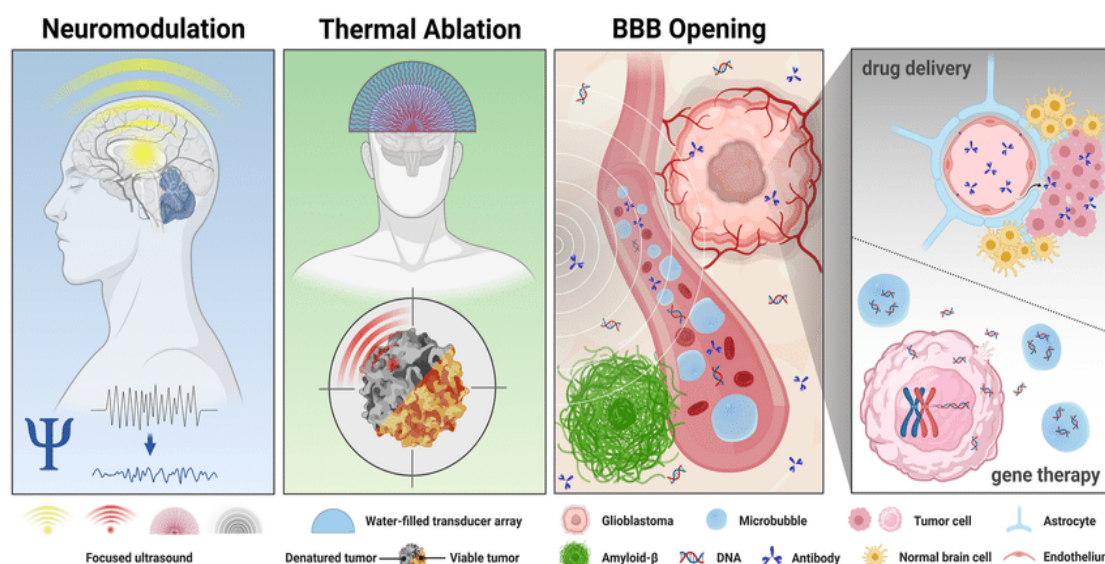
The applications of ultrasound neuromodulation (adapted from ¹⁵⁶).
